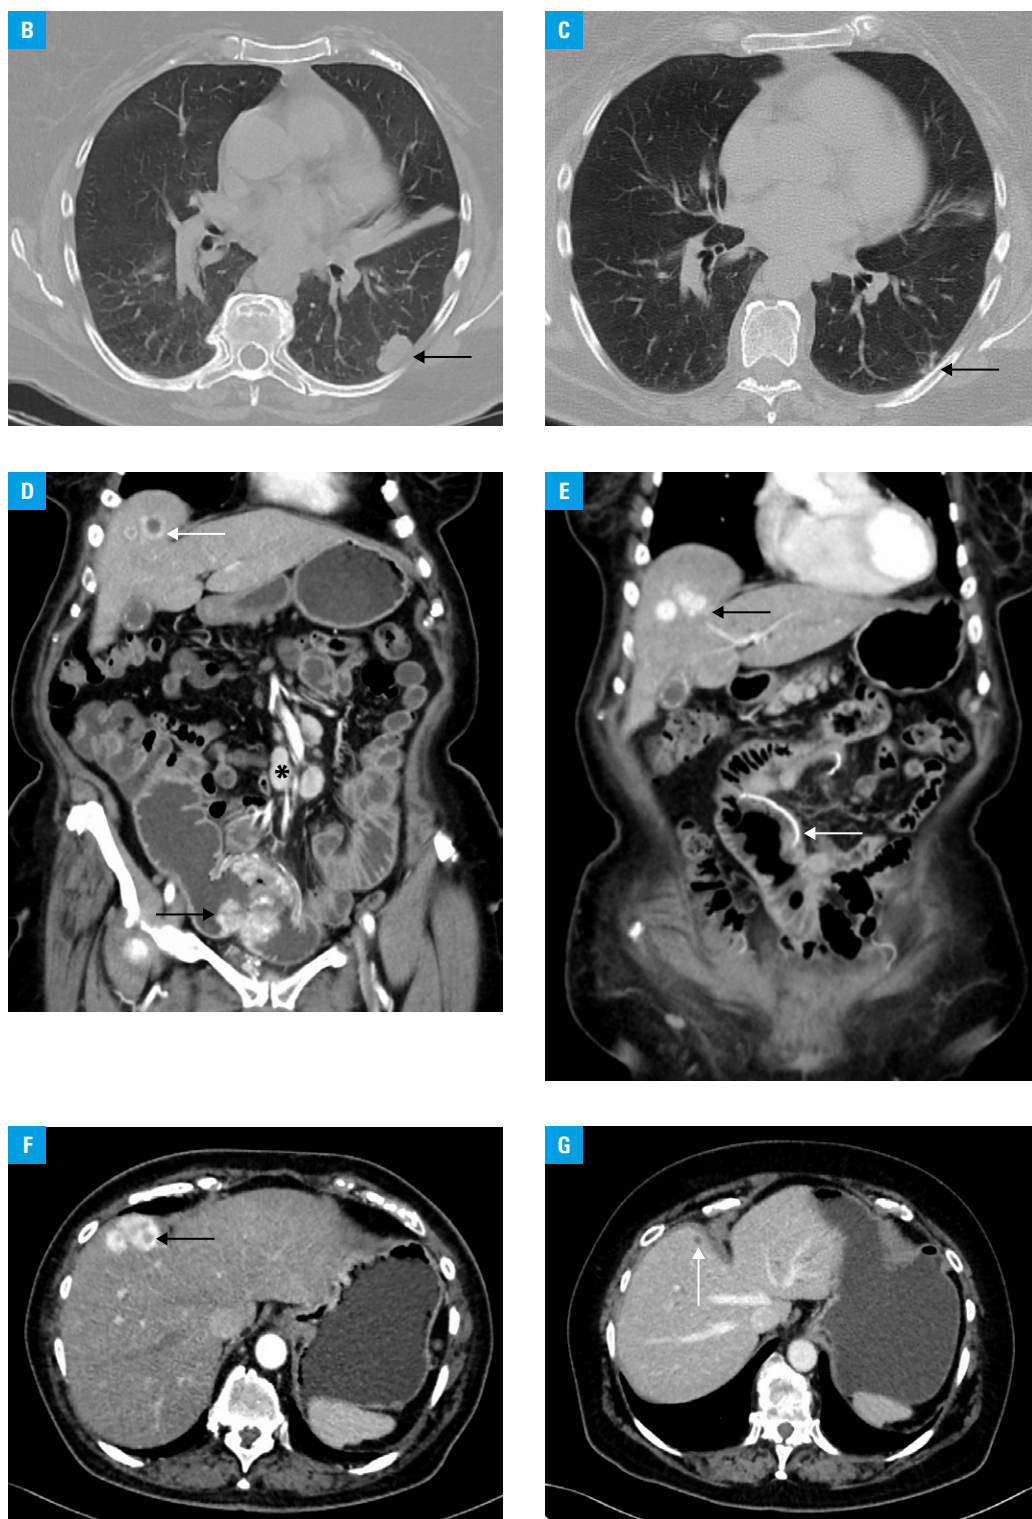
B – an axial CT scan with lung window settings showing subpleural metastatic lesion (arrow); C – an axial CT scan with lung window settings; arrow indicates spontaneous tumor regression with subpleural scar formation. D – a coronal CT scan with intravenous contrast administration revealing a hypervascular mass protruding into the lumen of the small intestine (black arrow), liver metastases (white arrow), and pathologic mesenteric lymph nodes (black star); E – a follow-up CT scan after surgery with white arrow showing surgical sutures in enteroenteric anastomosis, and black arrow indicating slight enlargement of tumors in the liver; F – a baseline axial CT scan prior to administration of pazopanib, with arrow showing a solid, hypervascular metastatic lesion in the liver; G – a follow-up axial CT scan performed 28 months after pazopanib treatment was commenced, with arrow pointing to a small hypovascular residual liver nodule
